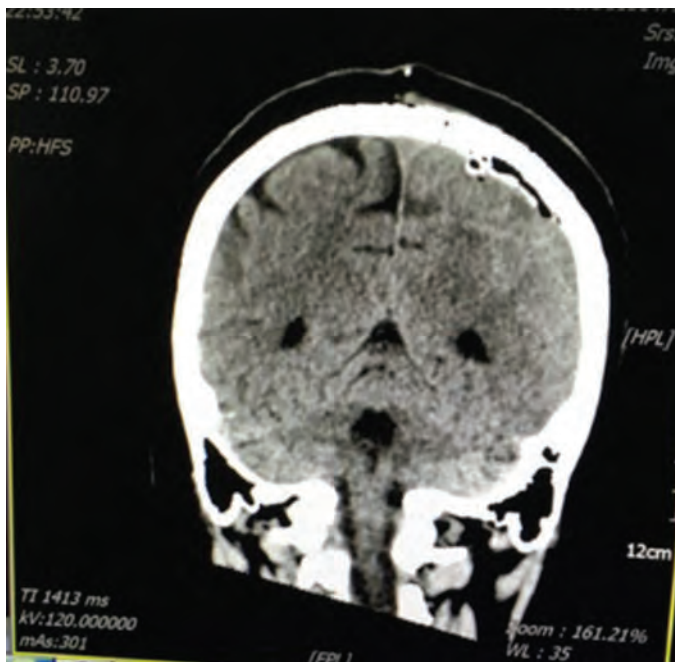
Cranial CT; minimal effusion at subdural distance in the left occipital region and widespread edema in the left hemisphere
